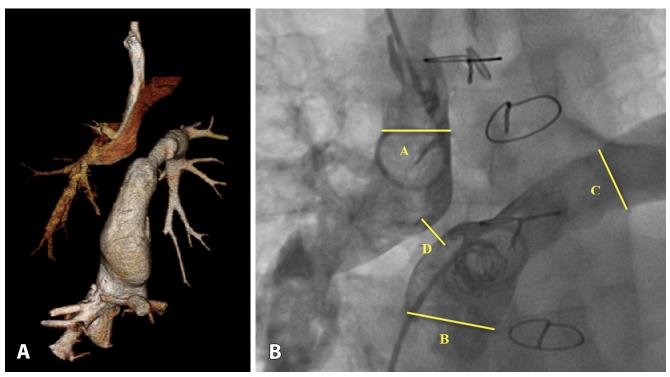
Panel A. Pre-procedure computed tomography scan and Panel B. Pre-procedure angiogram showing the Glenn anastomosis with superior vena cava connected to the right pulmonary artery (A=14 mm); Fontan conduit (inferior vena cava, B=18 mm; left pulmonary artery C=13 mm). The distance between the disconnected Glenn and Fontan anastomoses is D=5 mm.
